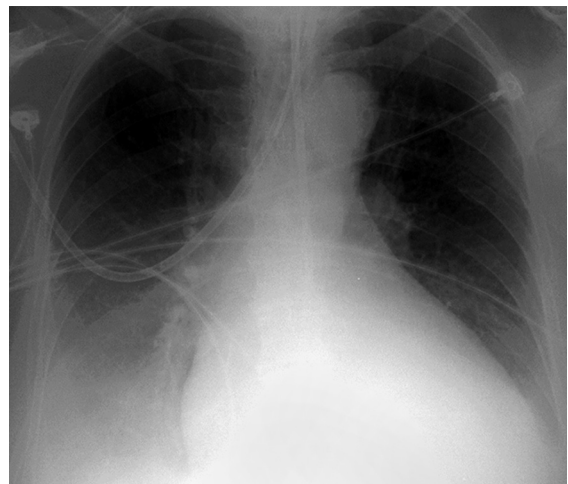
X-ray findings—usually shows prominent pulmonary blood vessels. Development of Kerley B lines, which are seen in the right base. These Kerley B lines are horizontal and start at the periphery; they are usually 1 mm thick and 1 to 2 cm in length.
